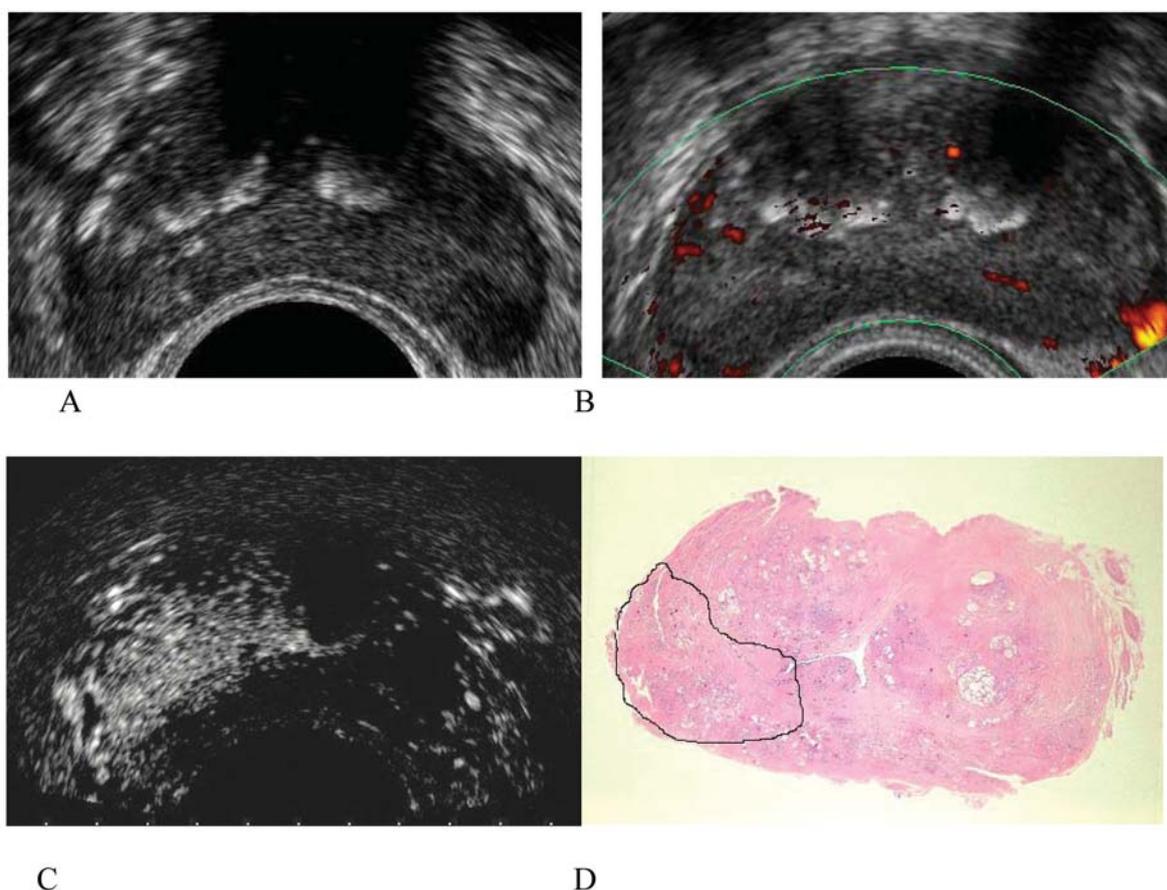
Role of CEUS in diagnostics of prostate cancer. A: Transrectal ultrasound examination in grey-scale mode; no sonographical signs of malignancy can be seen. B: Inconclusive zone of enhanced vascularization in the right lobe in the vicinity of the lateral contour. C: After intravenous administration of contrast medium, a wide zone of enhanced vascularization in the right lobe is visible of a size corresponding to the morphologically identified tumour spread. D: Boundaries of the corresponding section of prostate cancer are marked in the histotopogram.
